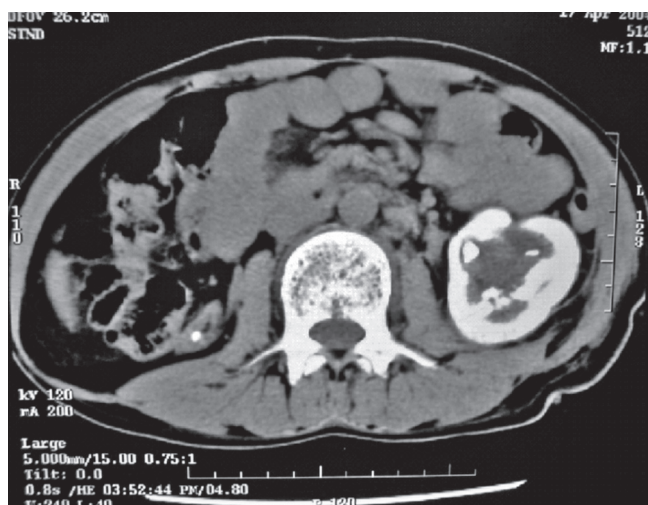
Noncontrast computed tomogram showing stones in both the kidneys and calcified left kidney. The right kidney showed postobstructive atrophy and became nonfunctional before the patient developed renal failure
